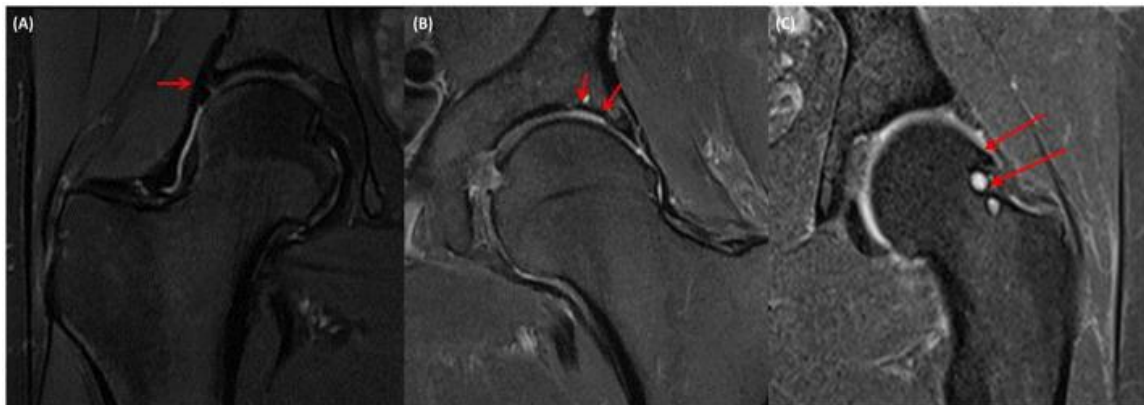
Imaging of the hip using coronal MRI revealed a labral tear, a cartilage lesion, and radial reformatting MRI indicating cam deformity and impingement cysts at the femoral head-neck junction.
